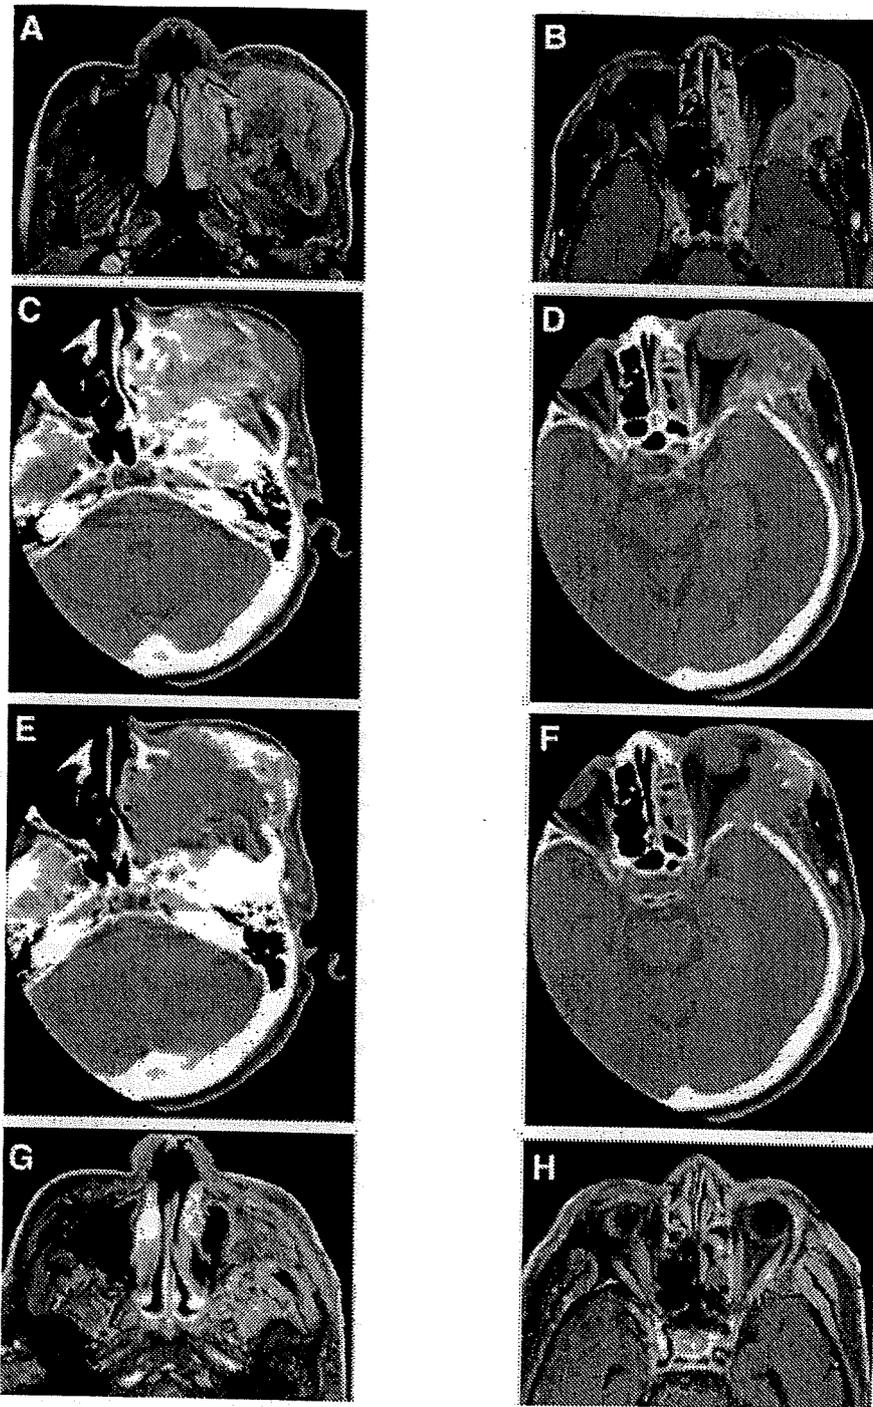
(A and B) Findings from a 70-year-old man with a left maxillary sinus cancer classified as T4bNOMO are shown. (C and D) Tumor enhancement was identified with intra-arterial computed tomographic arteriography (IA-CTA) of the internal maxillary artery. The facial tissue that was anterior and lateral of the maxillary sinus was not found to be enhanced. (E and F) IA-CTA of the transverse facial artery confirmed that this area was enhanced by the transverse facial artery. (G and H) Magnetic resonance imaging scans indicated the disappearance of the tumor 5 months after the completion of therapy. Tissue noted in the maxillary sinus was considered to be scar tissue. The patient was alive without disease after 30 months of follow-up.
